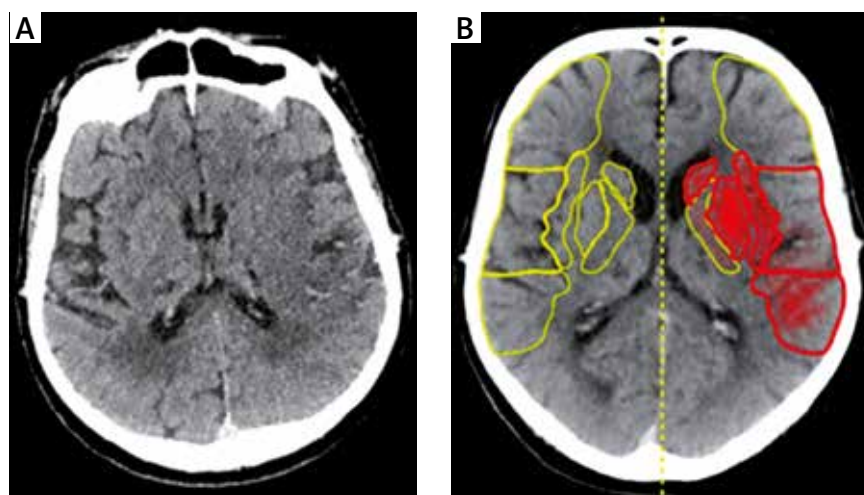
A) A 66-year-old male patient hospitalized for severe COVID-19 with a clinical manifestation of stroke for 3 hours. This patient was transferred from another hospital to our centre. Non-contrast CT scans show the features of a large infarct in the left cerebral hemisphere, including the loss of insular ribbon, obscuration of lentiform nucleus, loss of grey-white matter differentiation. B) e-ASPECT highlights the acute ischemia within ASPECTS regions (ASPECT score – 5). Authors' own material.
